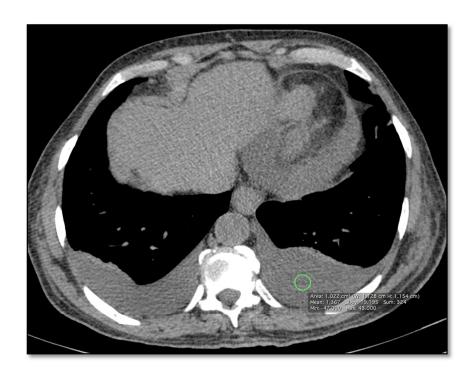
CT plain axial section showing mild bilateral pleural effusion with associated pericardial effusion in patient with congestive cardiac failure
